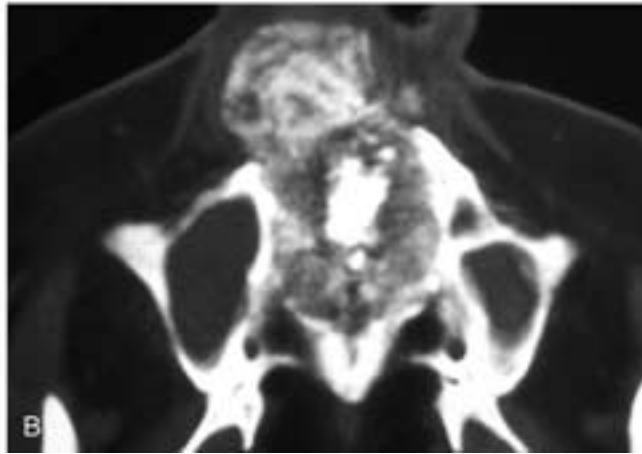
Coronal (A) and axial (B) CT scans show a bulky mass arising in the hard palate and extending ventrally into the nose. There are innumerable calcifications spread throughout the tumor. This patient had a chondrosarcoma.
